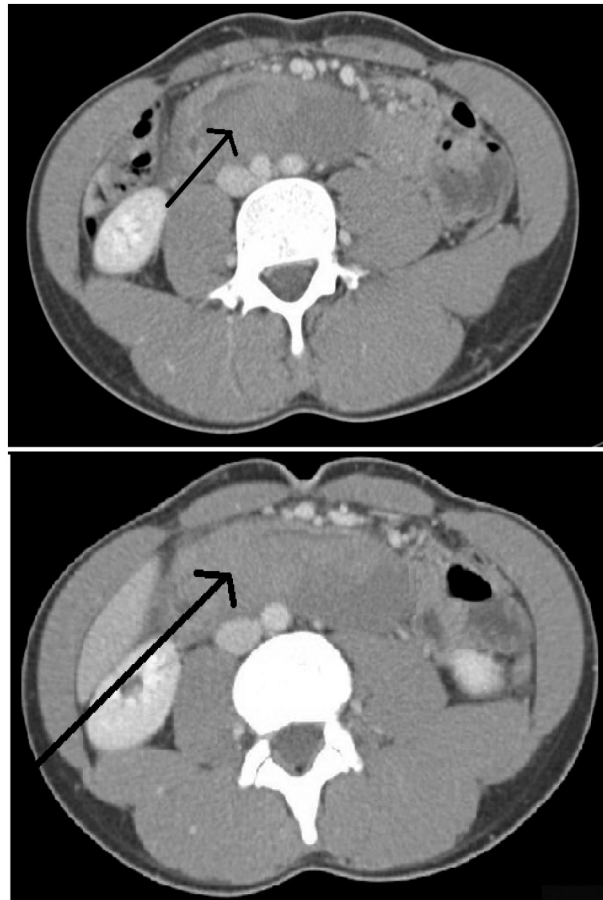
Contrast enhanced CT Axial view images showing duodenal hematoma.
